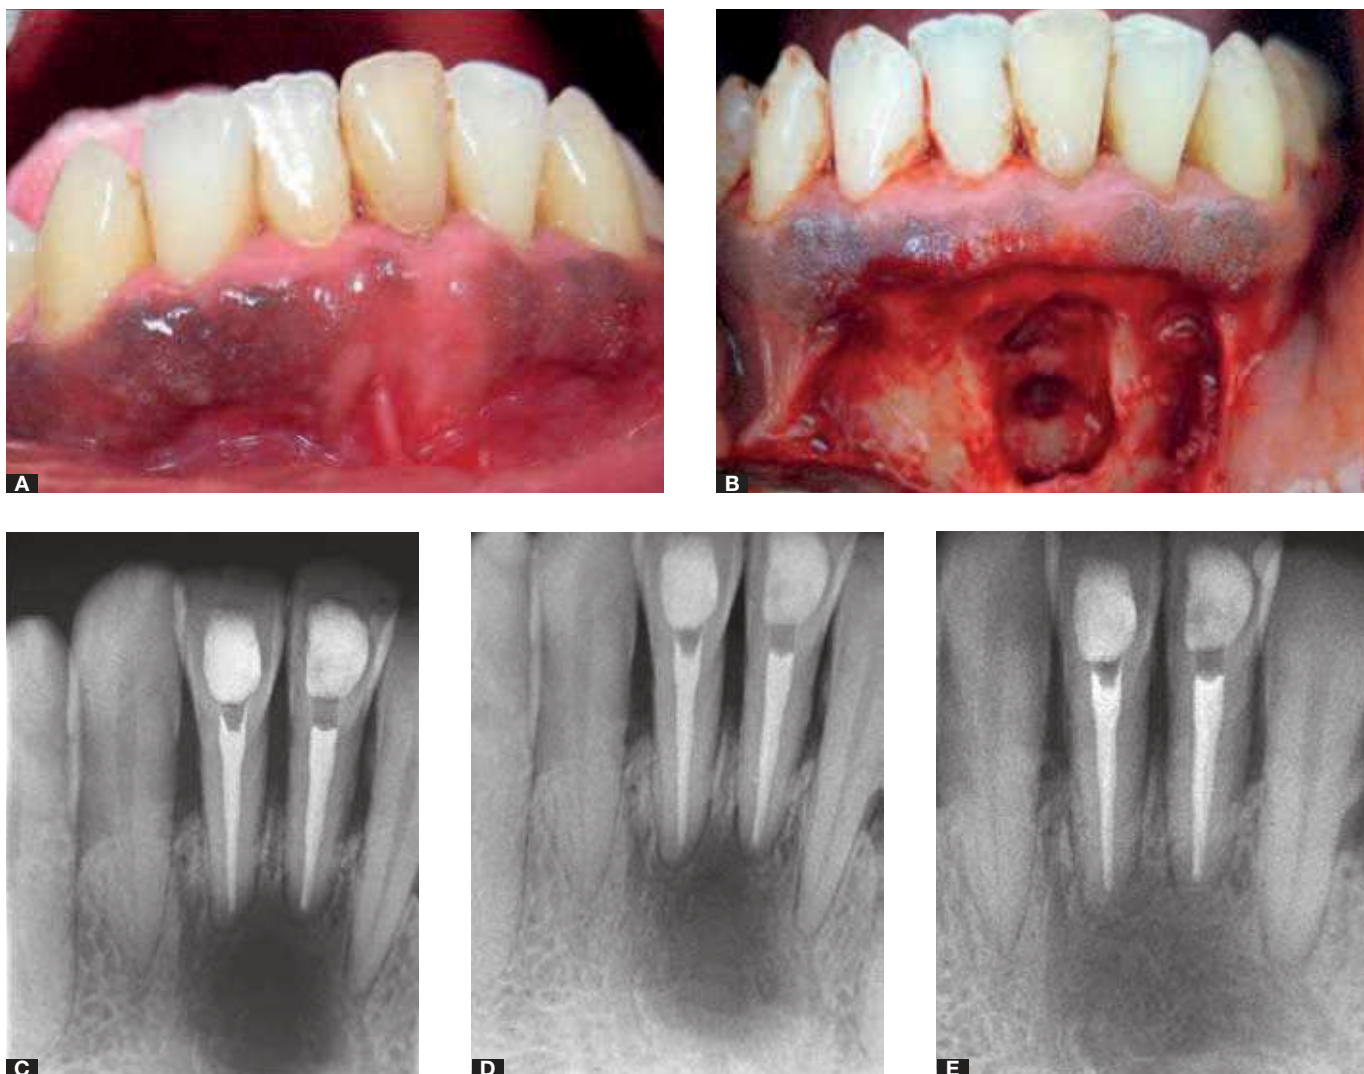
A) Pre-operative clinical aspect. B) Newman's surgical access flap. Clinical aspect after bone lesion curettage and 3 mm apicoectomy. C) Immediate post-operative radiograph. D) Six month review radiograph. E) Twelve month review radiograph.
